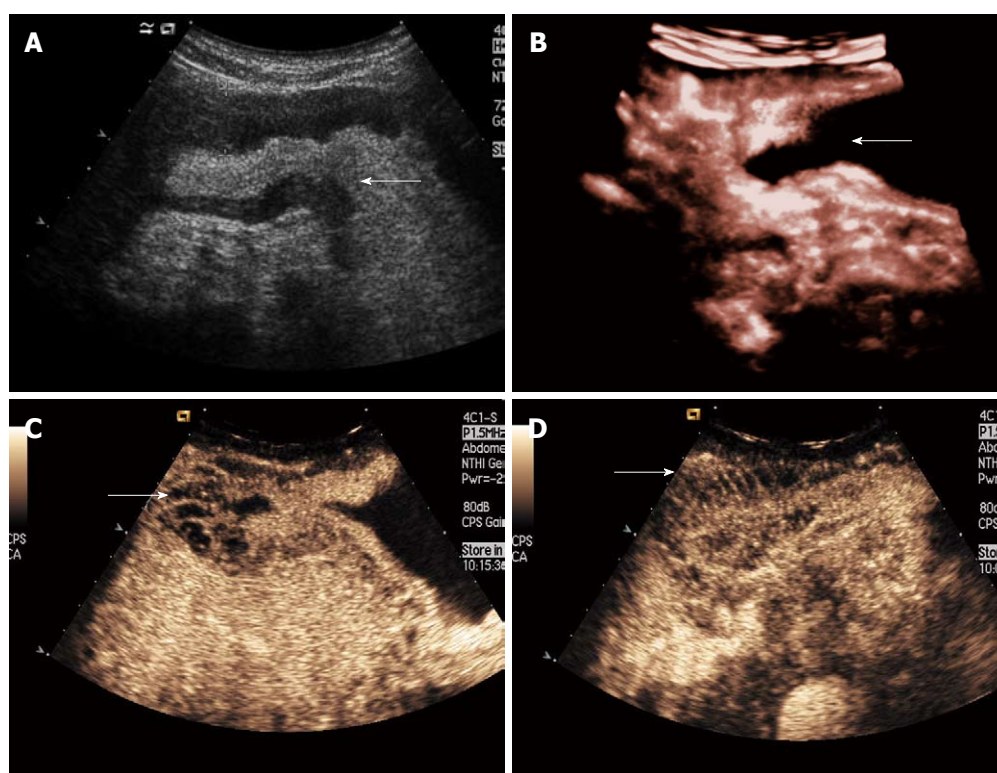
Double contrast-enhanced ultrasound imaging of infiltrative gastric cancer. A: An oral contrast image showed diffusely thickened gastric wall with narrowed gastric cavity (arrow) in a patient with gastric cancer; B: Three-dimensional double contrast-enhanced ultrasound (DCUS) imaging showed thickened gastric wall and narrowed echo-free gastric cavity (arrow); C, D: Two-dimensional DCUS images showed fence-like tumor vessels penetrating through thickened gastric wall in the arterial phase (arrows).
